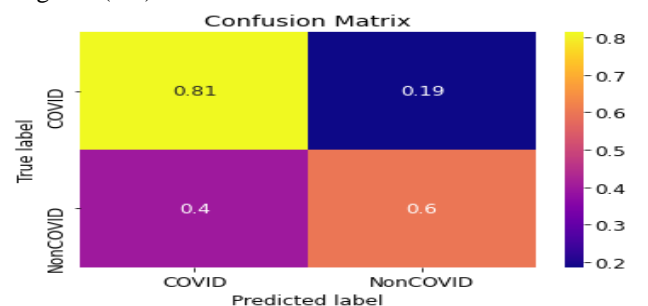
Confusion Matrix of Xception model for CT-Scan images
